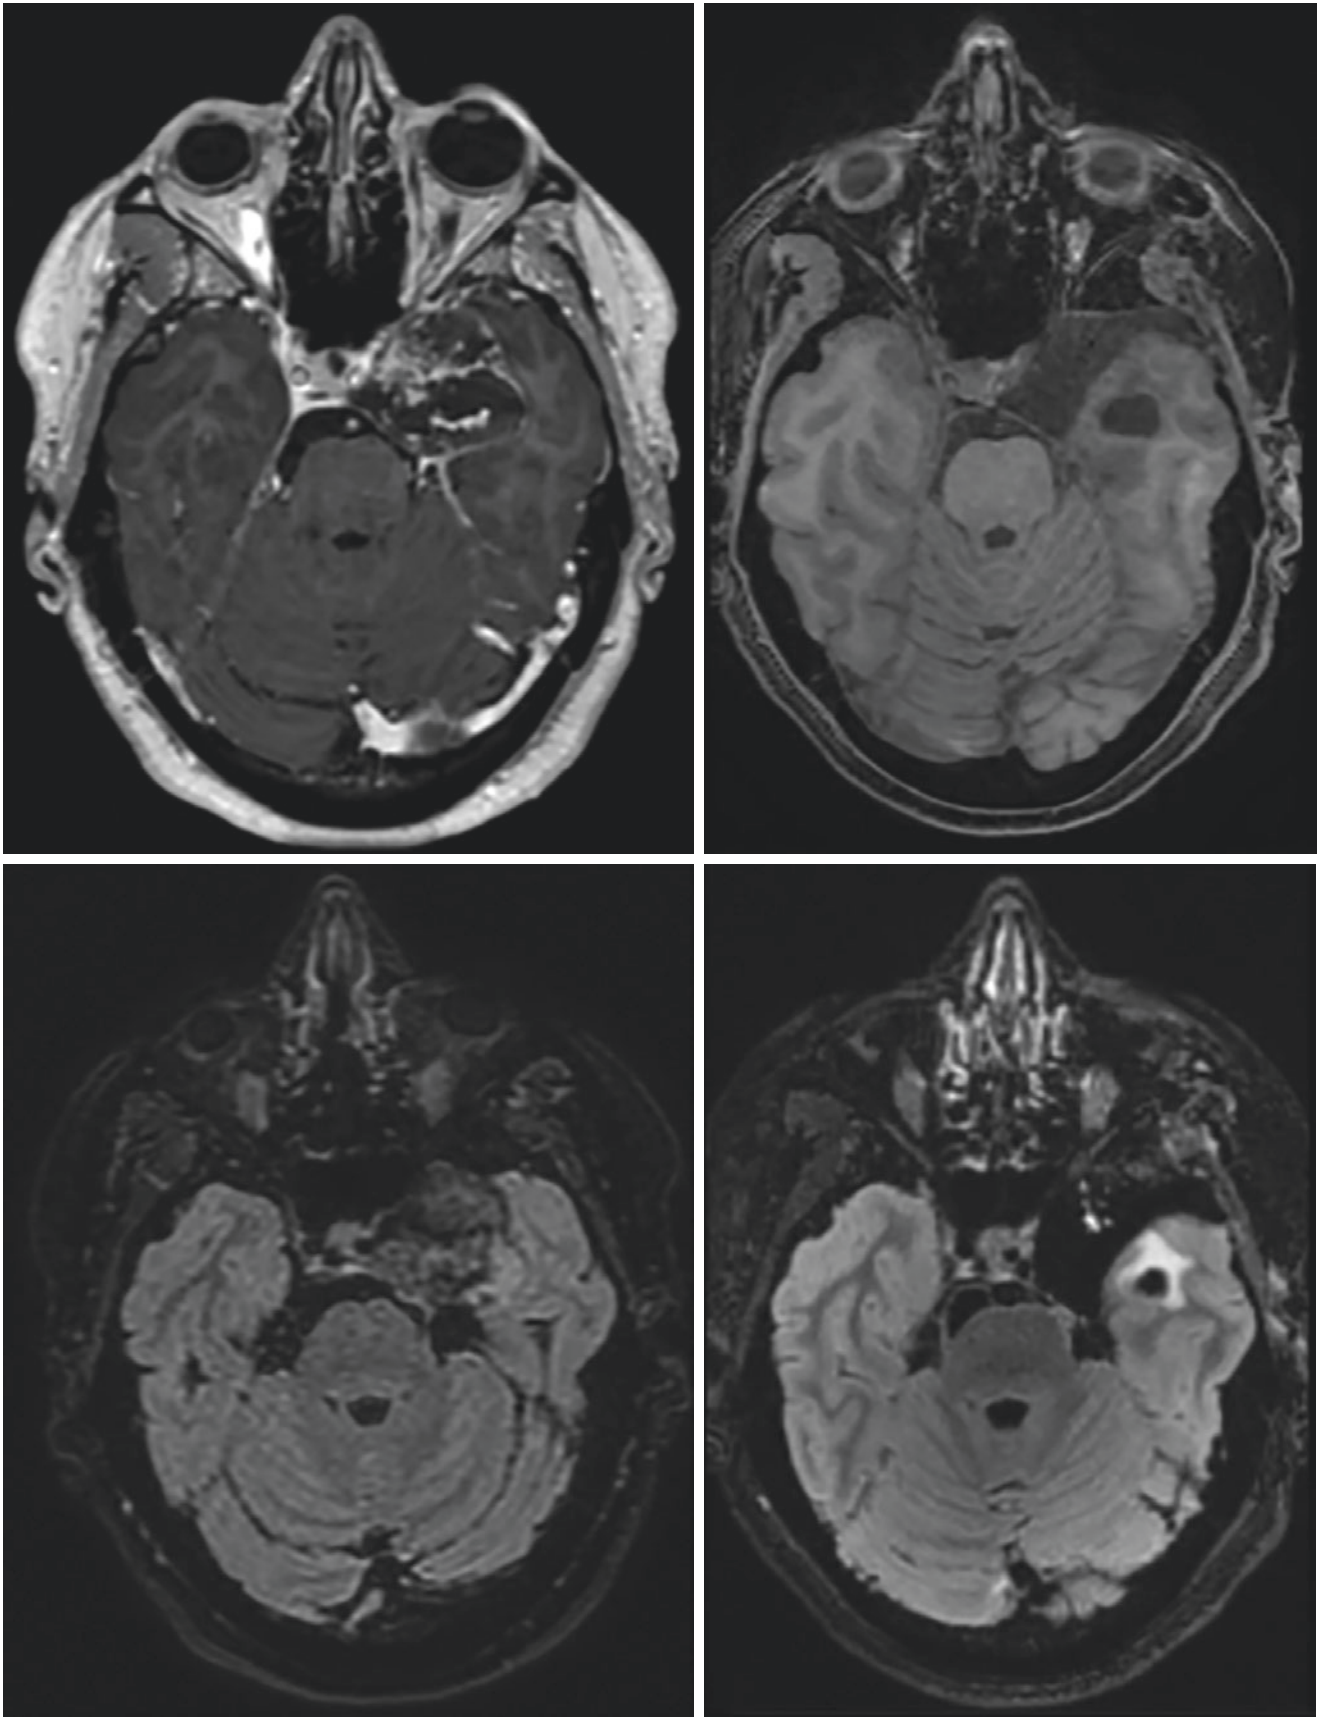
Comparative MRI images of pre-operative lesion (left column) and post-operative images (right column). No residual tumor is apparent and complete left temporal lobe integrity is noticed
